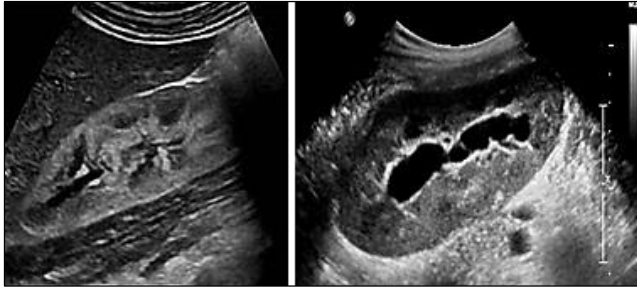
Glomerulonephritis ultrasound
